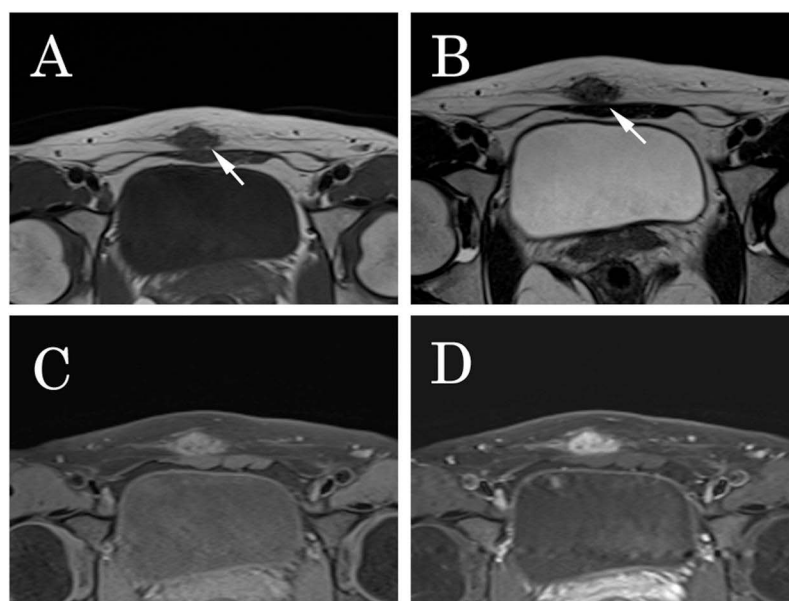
A 31-year-old woman with abdominal wall endometriosis which arose from the cesarean section scar (Case 3). The preoperative magnetic resonance imaging showed a 3-cm ill-defined mass in the subcutaneous fat. On T1- and T2-weighted images, the tumor was isointense compared with the muscle (A and B). On contrast-enhanced T1-weighted imaging, the tumor was enhanced homogeneously (C and D). The lesions contained small foci, showing hyperintensity on T1- and T2-weighted images (arrows).
